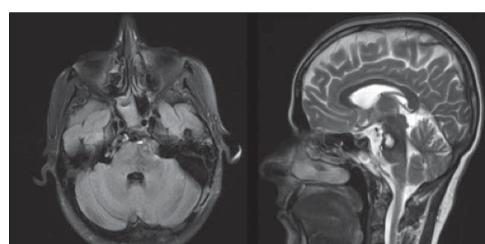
MRI taken two months after surgery (axial image on the left and sagittal on the right)
